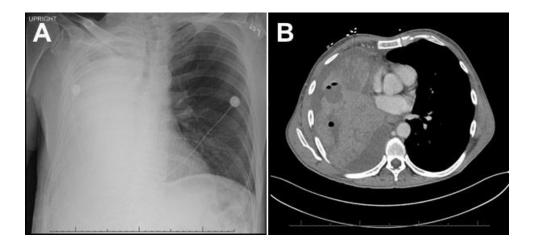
Panel A: chest x-ray post-thoracentesis showing reaccumulation of fluid. Panel B: representative panel from thoracic CT scan in soft tissue windows.
